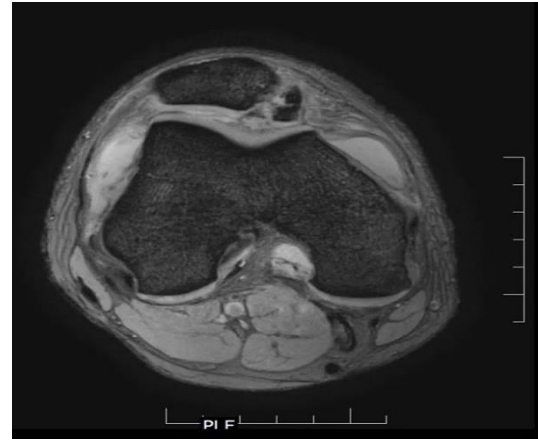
Axial magnetic resonance imaging (MRI) of knee showing comminuted osteochondral fracture of the right patella
